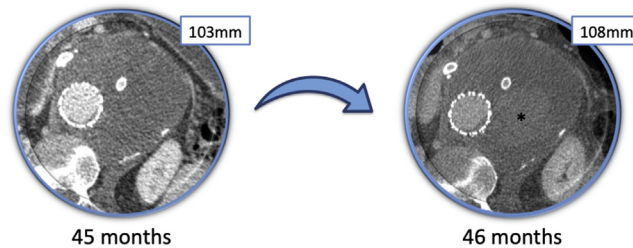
Computed tomography angiography (CTA) axial images of maximum aneurysm diameter, demonstrating a 5-mm growth during 1 month and new fresh blood products (*asterisk*) that were also noted on non-contrast-enhanced imaging.
